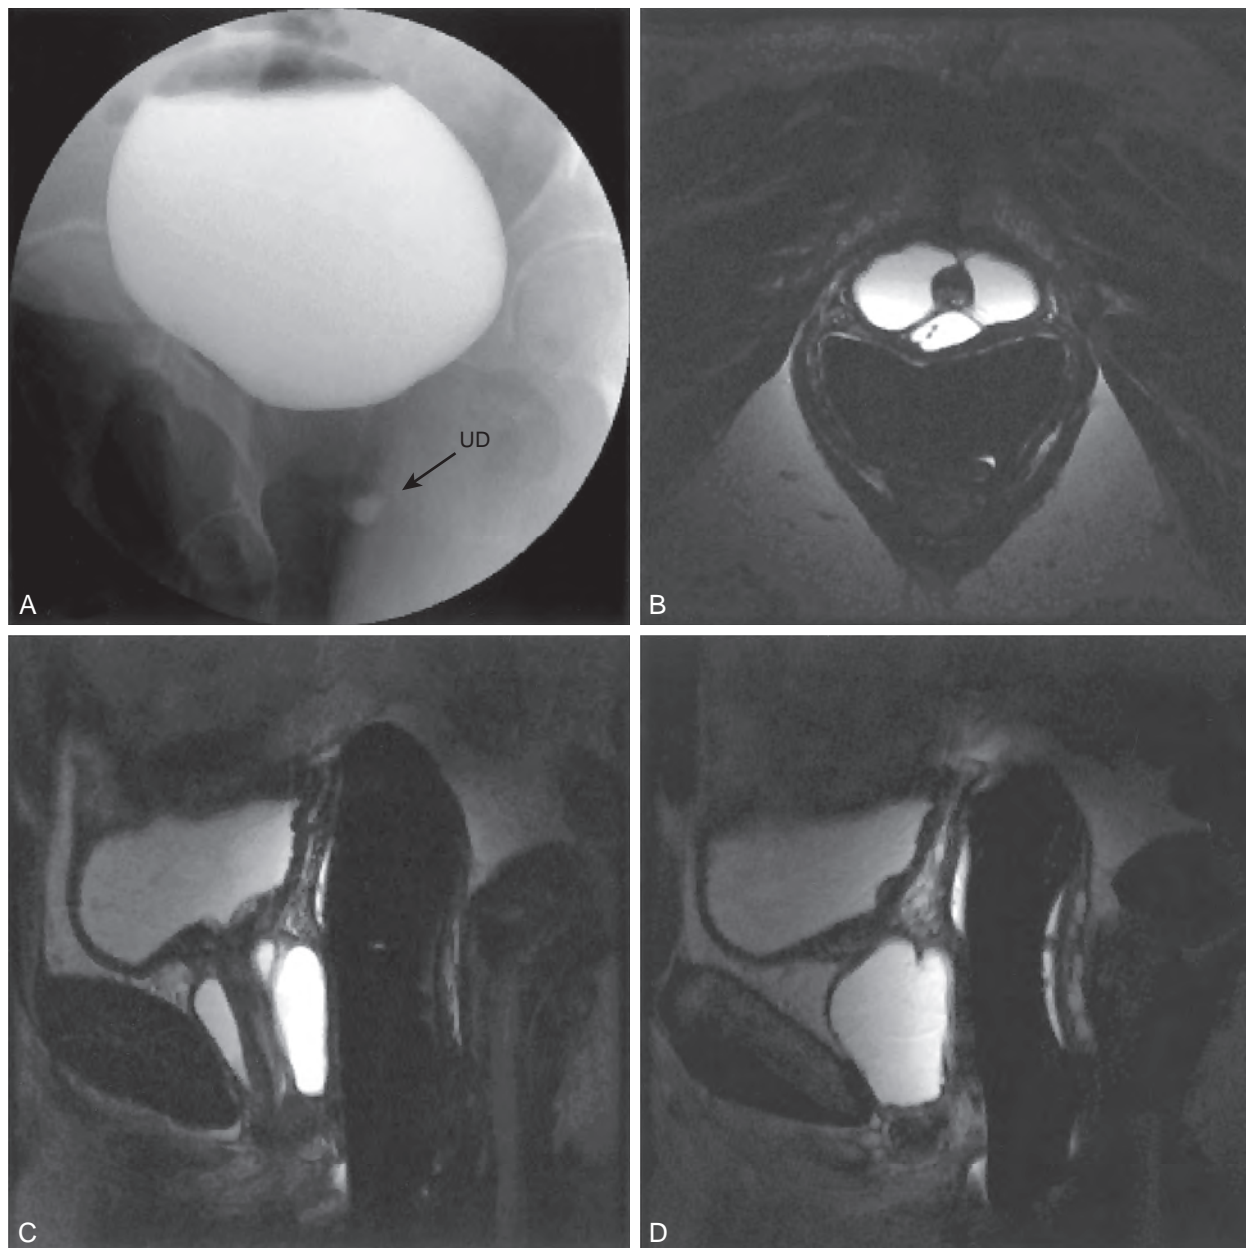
Voiding cystourethrogram (VCUG) and magnetic resonance image (MRI) from a patient with a large circumferential urethral diverticulum (UD). A, The voiding image from the VCUG shows poor opacification of the proximal urethra with suboptimal distention of the UD as a result of a poor voiding effort. B to D, The endoluminal MRI demonstrates the full extent and complexity of the lesion on the T2 axial (B), midline sagittal (C), and parasagittal (D) images.
